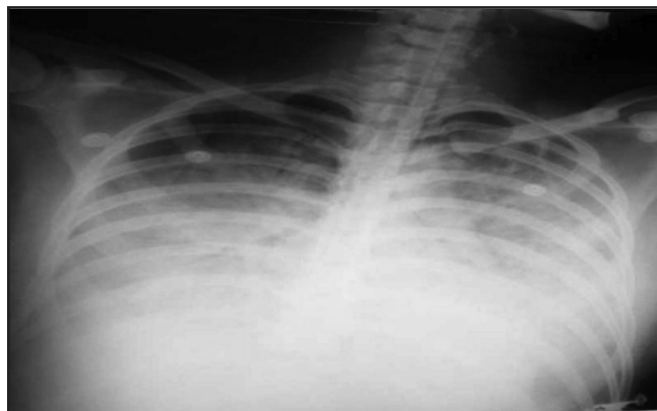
Chest X-ray film repeated at 2029H shows diffused opacity in bilateral lung fields extending up to mid zones consistent with pulmonary haemorrhage.
